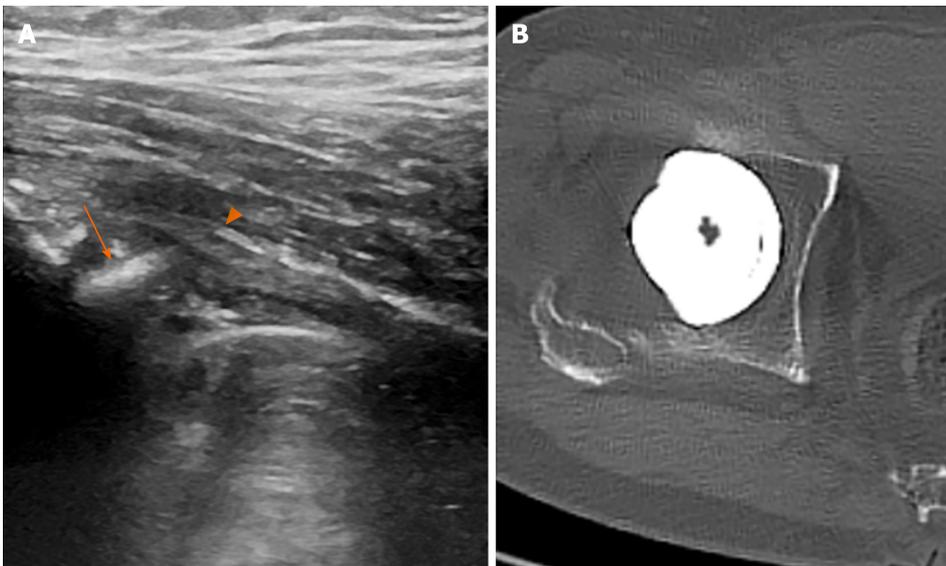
Images showing potential iliopsoas impingement by the cup. A: Ultrasonography demonstrating a protruded acetabular rim (arrow) in approximation to the iliopsoas tendon (arrow head); B: Axial computed tomography scan showing a retroverted cup by 9°.
